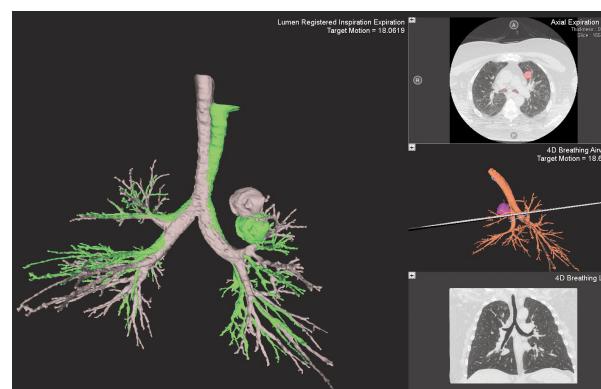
3-D reconstruction of the bronchial tree made from paired full-inspiration (grey) & tidal volume-expiration (green) CT images. The left upper lobe nodule migrates 18 mm during the respiratory cycle.
